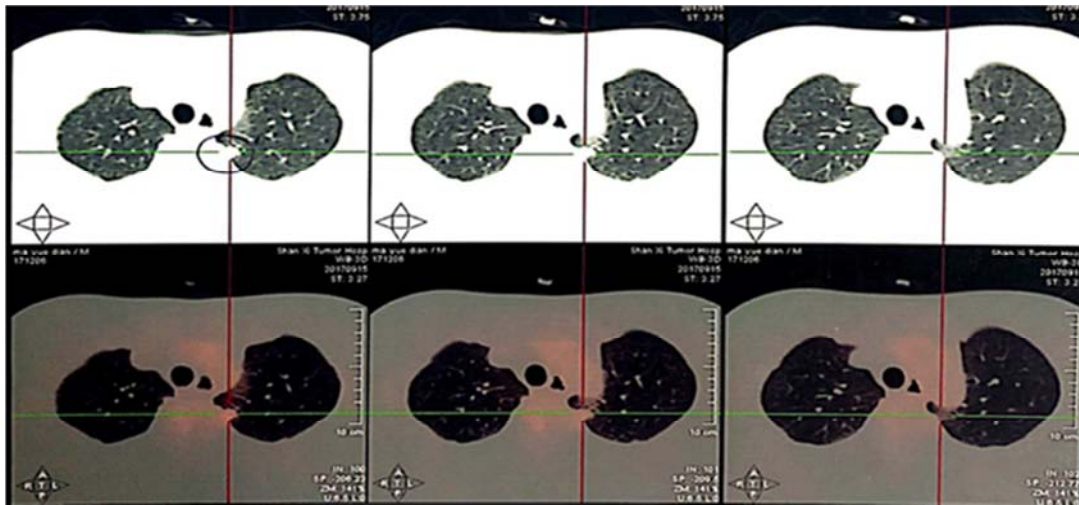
PET-CT of lung.
